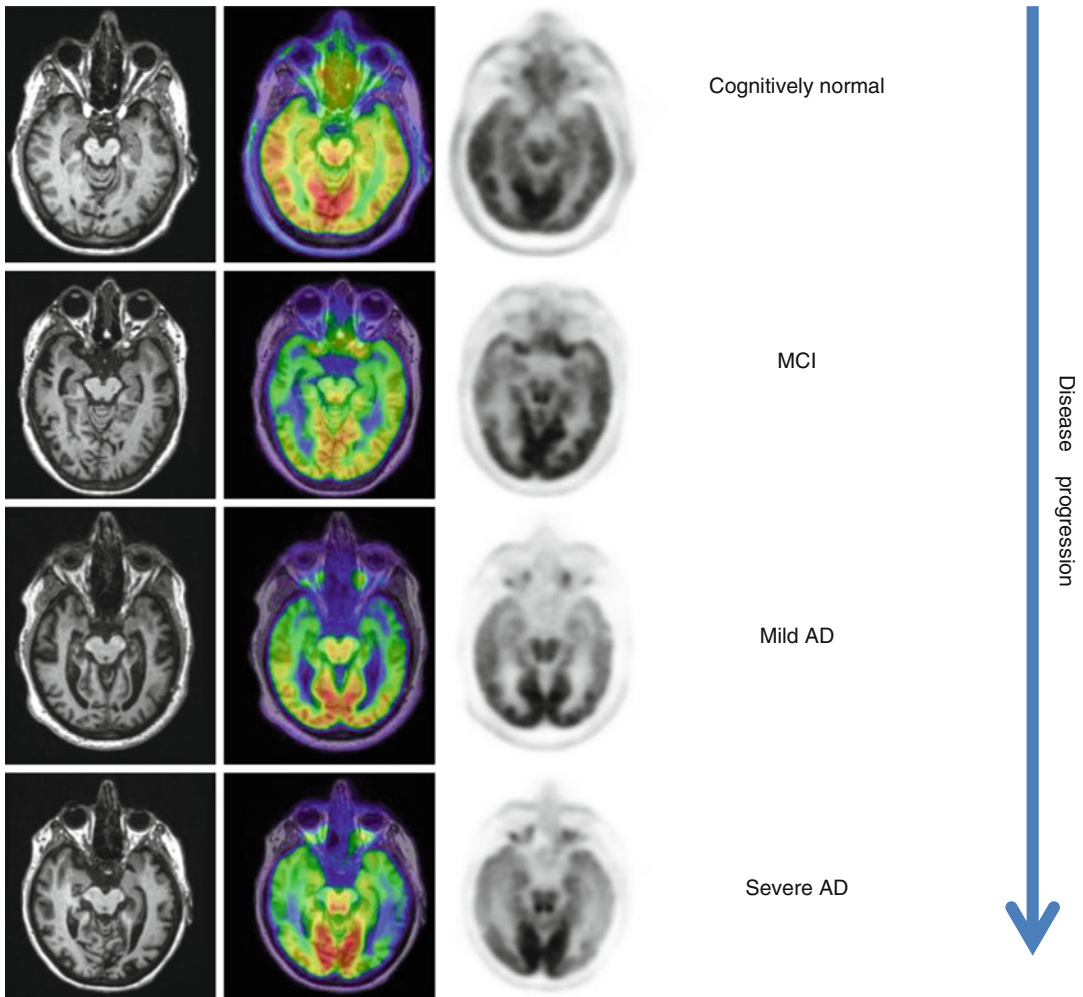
PET/MR imaging showing the progression of temporal atrophy and hypometabolism at different stages of cognitive impairment (Images are courtesy of IRCCS SDN, Naples)
